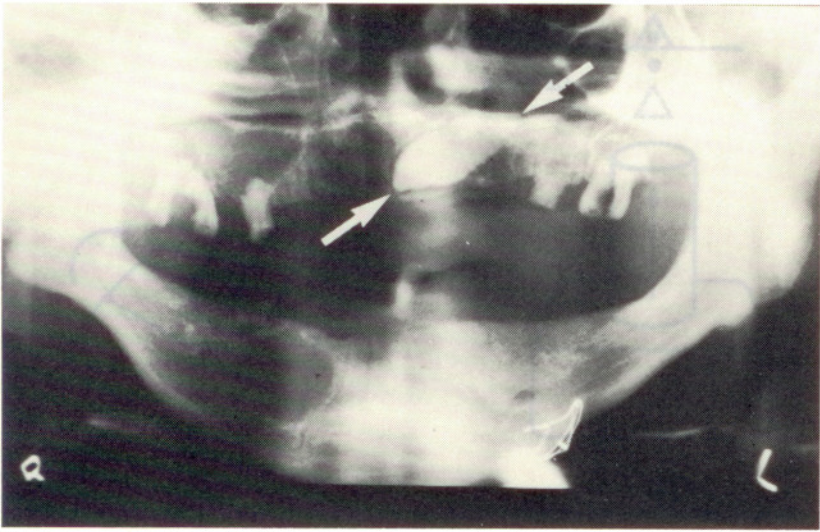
Panoramic radiograph showing grossly enlarged image of cuspid in maxilla. This enlargement demonstrates its palatal position.
